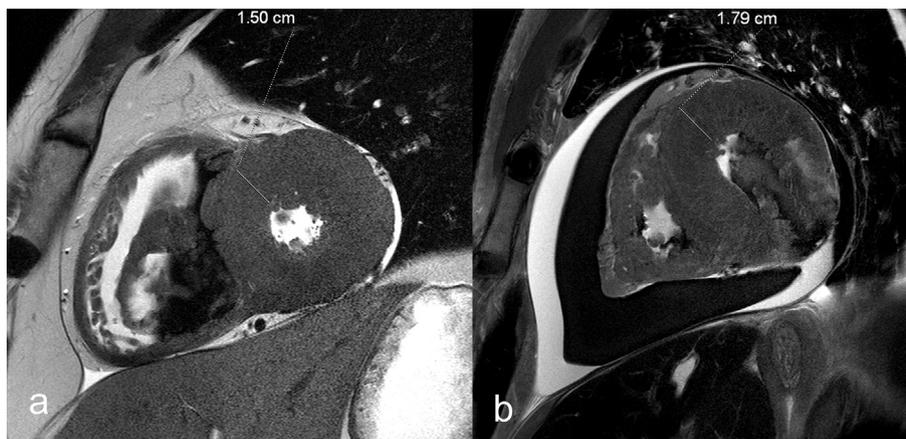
Anterior left ventricular wall thickness measurements on PMMR for comparison with autopsy measurements. Measurements of the anterior LVWT at the outflow tract in short-axis views on PMMR T2-weighted turbo echo sequence of a case without (a) and a case with (b) pericardial effusion.
